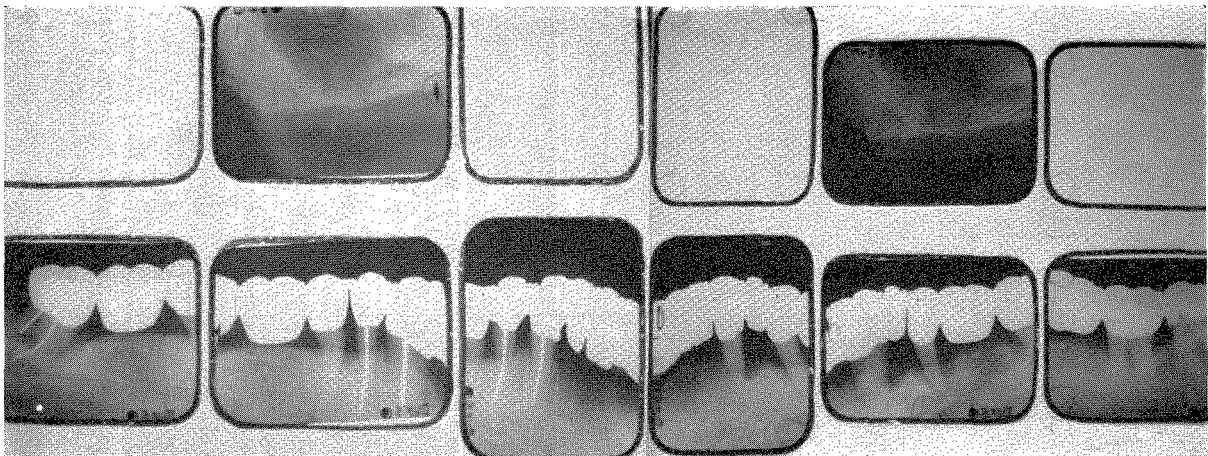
The roentgenograms taken in October, 1960. This bridgework was inserted two years previously. (See text.)
